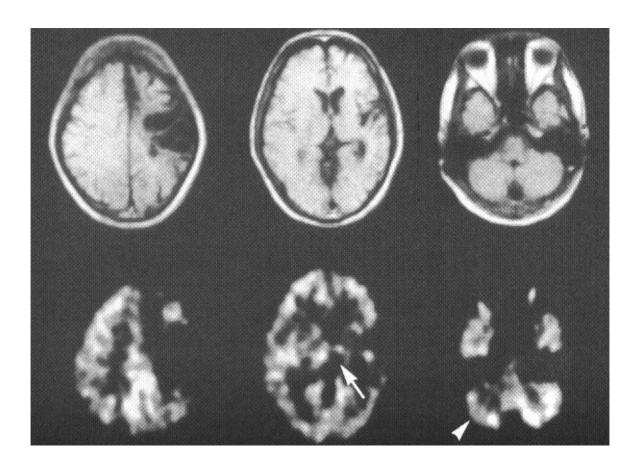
Representative appearances of MRI and PET image data at the same brain slices from a 41-year-old man who had suffered from left cortical infarction 4 years and 2 months previously. Decreases of CMRGlc were observed in the left thalamus (arrow) and in the right cerebellum (arrowhead).
